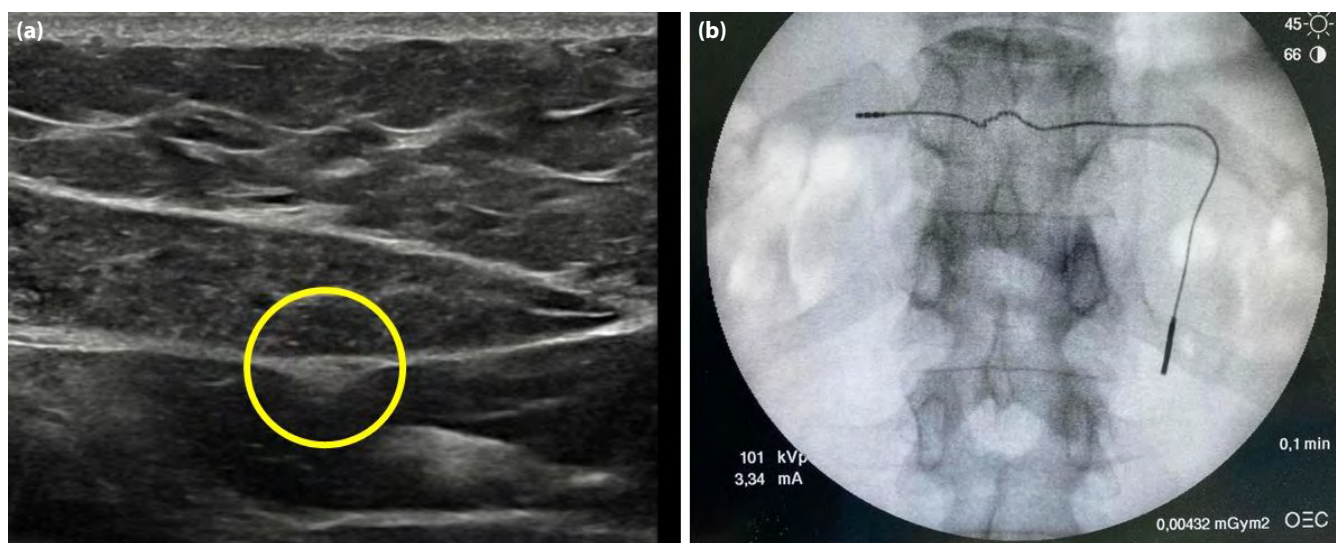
Ultrasound image of anterior cutaneous nerve and PNS implantation. (a) Ultrasound image of the anterior cutaneous nerve detection (yellow circle). (b) Fluoroscopic image of the catheter positioned with an “L” shape in order to enlarge and maximize the stimulation field.
